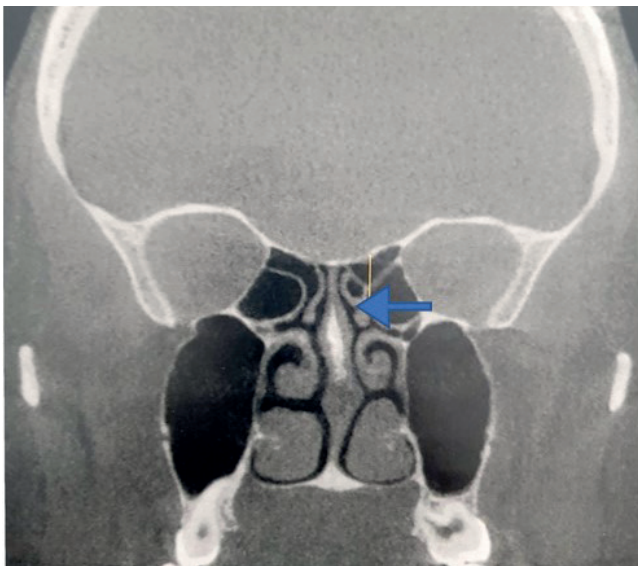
Tomographic (CT measurement) of the height of the position of the superior nasal concha on the lateral wall of the nasal cavity (blue arrow) in relation to the skull base
